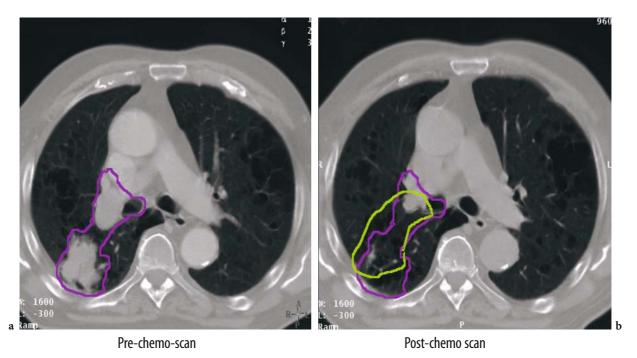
Target contouring on co-registered pre- (a) and post-chemotherapy (b) CT scans. The *pink contour* represents the GTV (tumor and hilar nodes) contour using 3D image registration. The *green contour* represents the contour drawn by a clinician, using non-matched hard copies of the pre-chemotherapy CT scans
